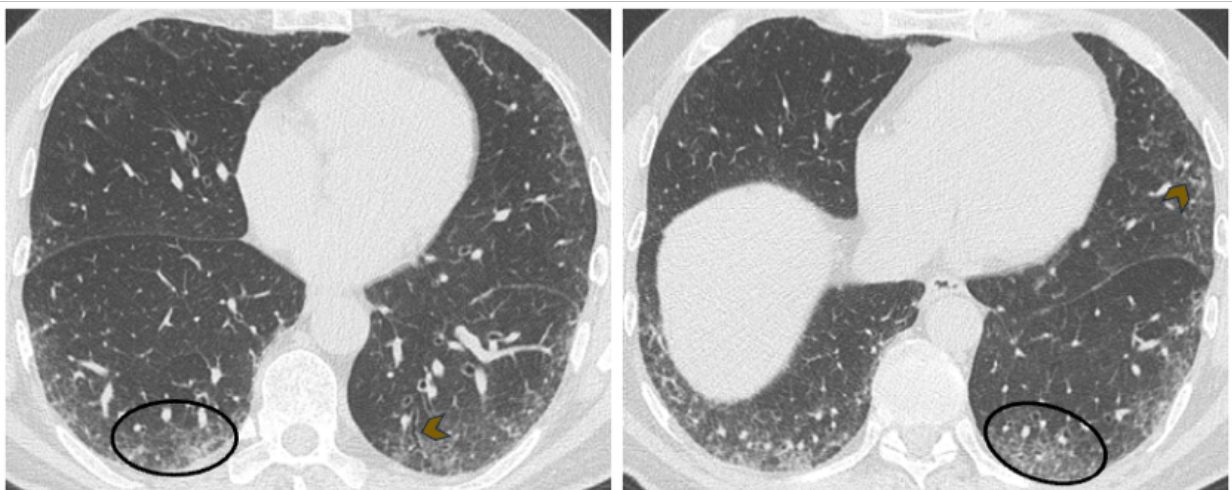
Axial CT images showing evidence of subpleural fibrotic ILA: bilateral traction bronchiolectasis (arrowheads) associated with ground glass opacities and reticulations (circles).
